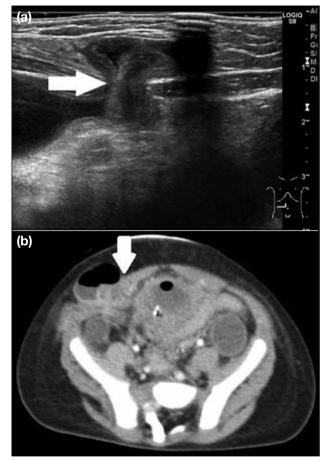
Trocar site hernia. This male patient presented with a recto-prostatic-urethral fistula with a high-type anorectal malformation at age 8 months. Laparoscopically assisted anorectoplasty was performed as the second surgical repair at age 8 months. Five days after surgery, the patient developed abdominal distension. Ultrasonography and computed tomography scan showed evisceration on a 5-mm trocar site, for which surgical repair was performed. (a) Axial sonogram showing evisceration of small intestine at trocar site (arrow). (b) Contrast axial computed tomography image showing small intestine evisceration at the trocar site (arrow).
